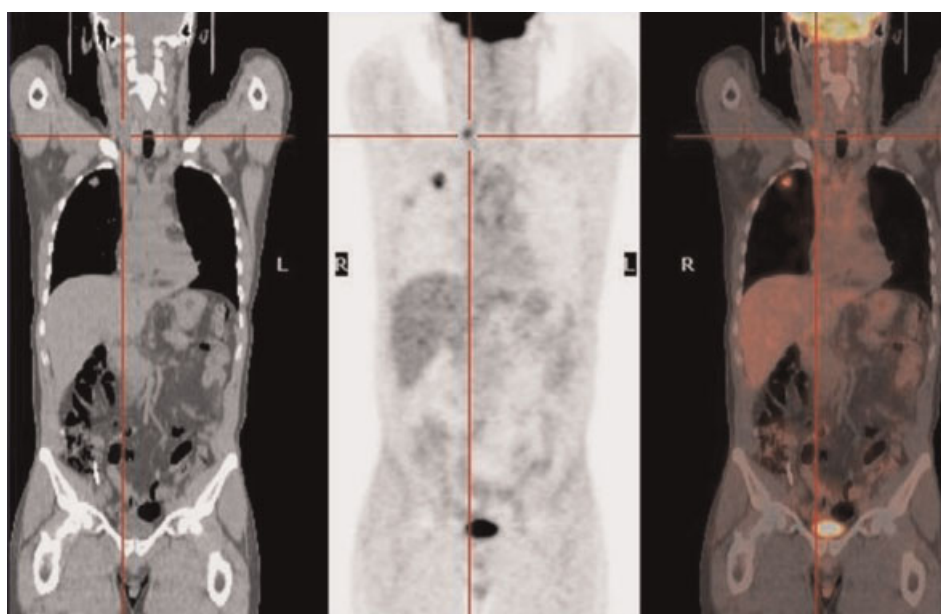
PET-CT. Patient with nonsmall cell lung carcinoma referred for staging with a right supraclavicular adenopathy that modifies the therapeutic management.
